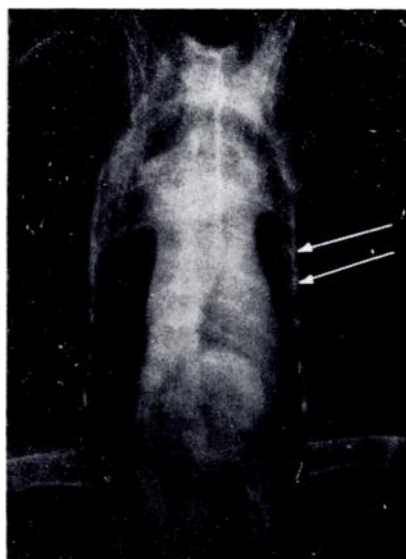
Post-mortem radiograph of the thorax and abdomen of the male. The arrows indicate two lesions.
